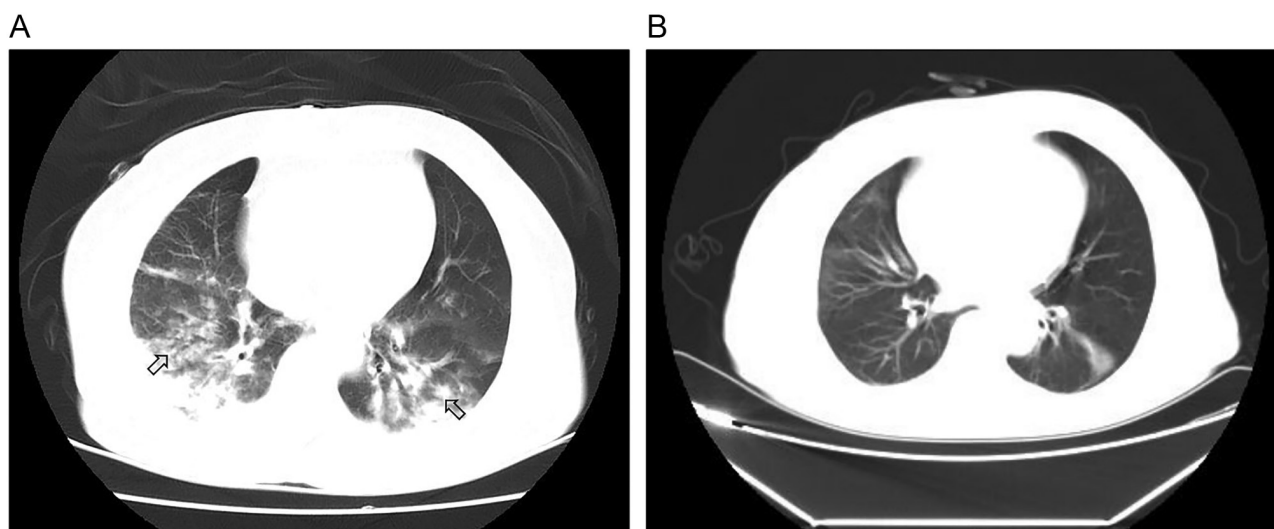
Chest CT of Case 2. (A) CT scan performed on arrival to the Emergency Department ~3 h after drowning, revealing both lung interstitial opacities with air trapping. (B) CT scan performed on the seventh day after treatment showed a few fibers cable shadows and pulmonary nodules. The arrows represent exudative changes in the lungs.
